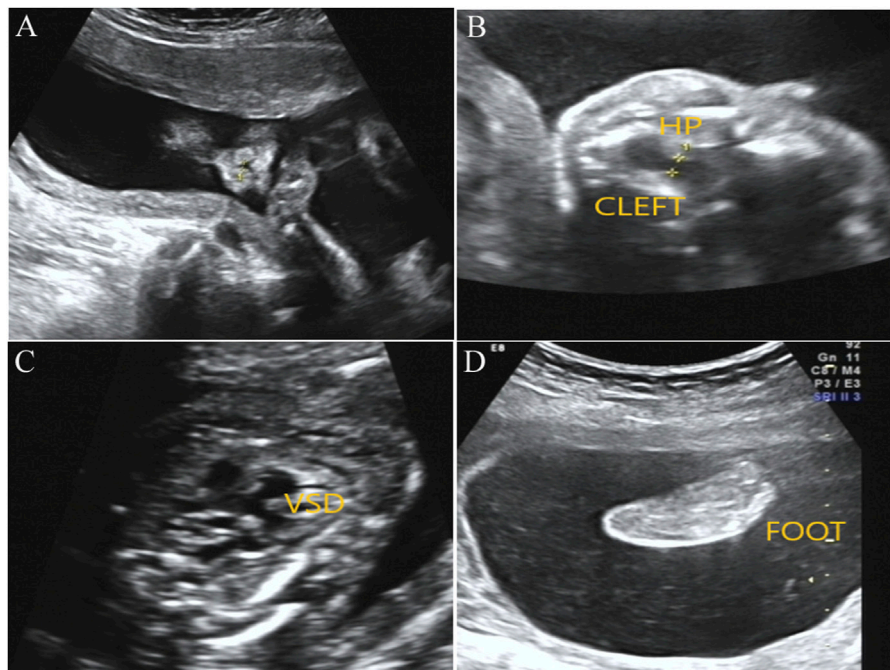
Prenatal ultrasound examination results in the fetus with *BCOR* variant. (A) Ultrasound detection results showed right alar fissure in the fetus. (B) Fetal ultrasound results indicated continuous interruption of cleft palate. HP, hard palate. (C) Fetal ultrasound results elicited fetal ventricular septal defect (VSD). (D) Toe syndactyly was also observed in the fetus by ultrasound examination.
